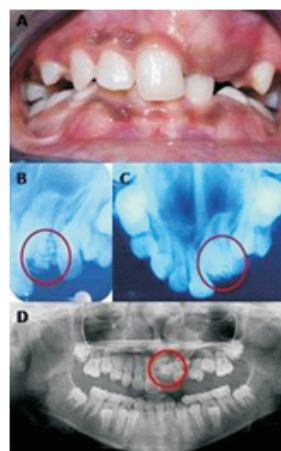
Case 1 - A. Preoperative intraoral photograph showing unerupted 21 and 22. B, C & D Intraoral periapical radiograph, occlusal radiograph and OPG depicting cluster of radio opaque masses
